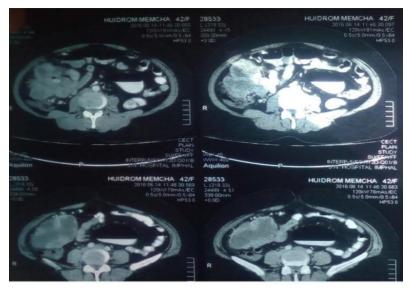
CT scan of abdomen showing the lesion over the right side of abdomen
